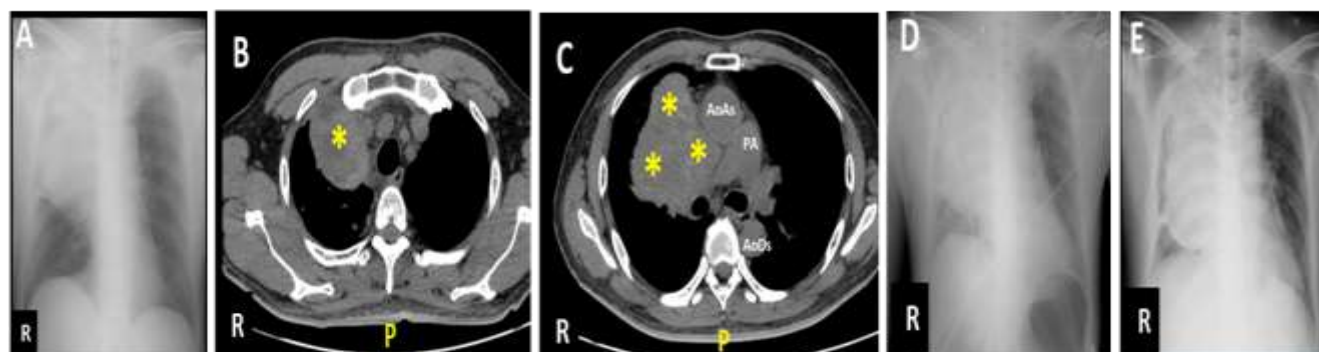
(A) Plain chest radiograph showing a lobulated opacity projected to the level of right Th1-8 paravertebral, suspicion of the right superior mediastinal mass, accompanied by a suspicion of the pneumonic type of pulmonary metastases. Thickening of the superior aspect of pleural space and thickening of the minor fissures directs the suspicion of pleural effusion-type metastases. (B) and (C) confirm the finding of a mass in the anterior mediastinum (yellow asterisk) which suppresses the structure of the superior vena cava and make a partial obstruction of the right bronchus. Multiple nodules in the superior lobe of the right lung with pneumonia. (D) Plain chest X-ray after the bypass procedure and (E) 3 days post-operative. PA, pulmonary artery; AoAs, ascending Aorta; AoDs, descending Aorta
